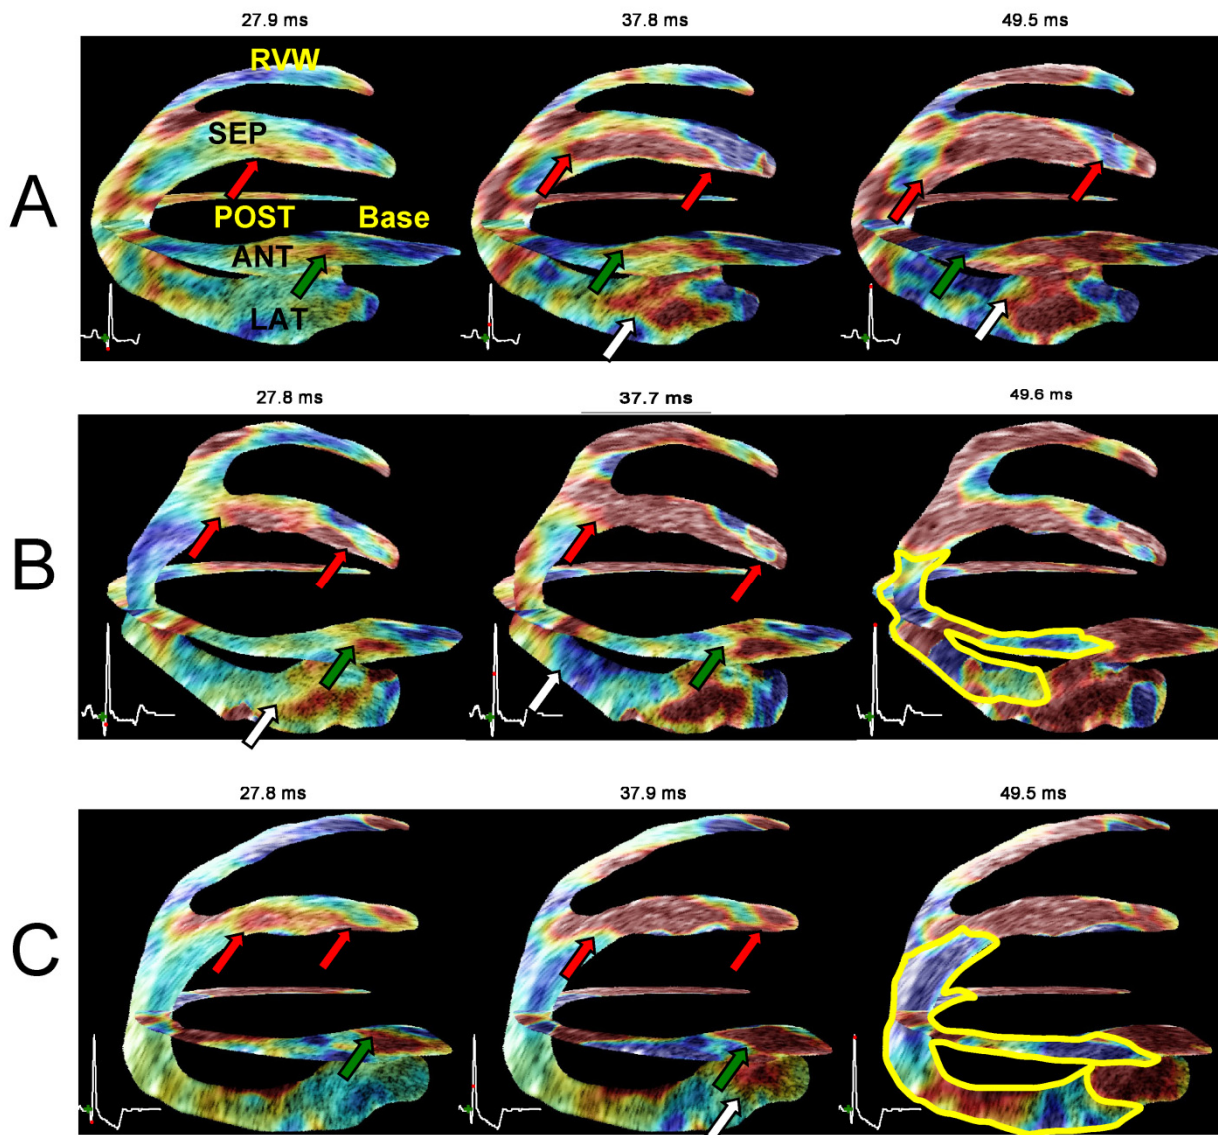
Bi-plane (two-chamber and four-chamber views) view of the same heart under different LAD coronary artery occlusion levels. Red, white and green arrows indicate the propagation of the EW in the septal, anterior, and lateral wall, respectively. (a) Without any occlusion, i.e. normal coronary flow, radial thinning is visible up to regions where the axial direction of the ultrasound beam coincides with the longitudinal direction of the cardiac geometry, where shortening is expected (in blue). (b) At 60% occlusion, this behavior is reversed in presence of ischemia: a region (delimited with a yellow line) containing radial thinning (blue) and longitudinal lengthening (red) is observed. (c) At complete occlusion this region increases in size. The ischemia is visible in the anterior, posterior and lateral wall near the apex at 60% occlusion and in the anterior, posterior, lateral, and septal wall at 100% occlusion. (Provost et al., 2010)
